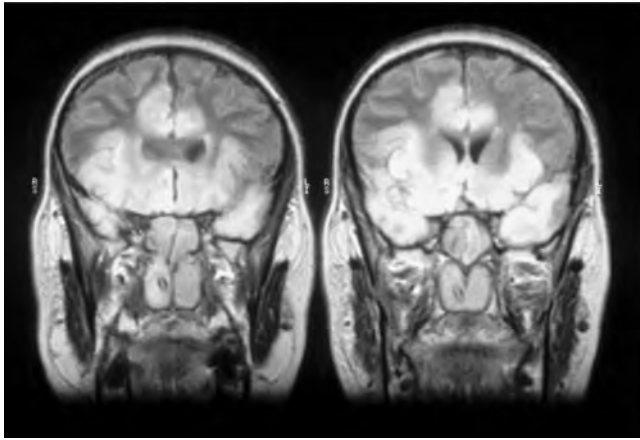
Fulminant herpes simplex encephalitis; extensive temporal lobe and diffuse parenchymal inflammation (MRI T2W).
